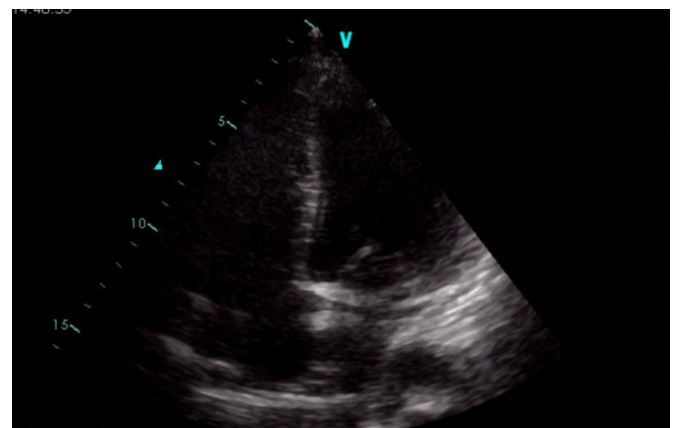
Transthoracic echocardiographic image after the surgical repair.
